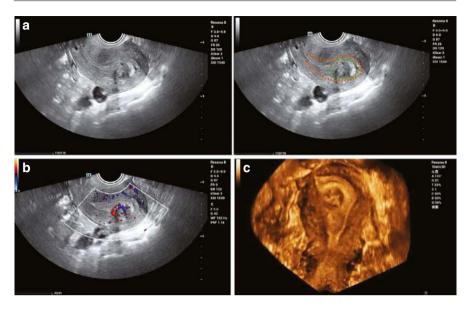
(a) Type 0 fibroid: B-mode ultrasound shows a submucosal fibroid that protrudes from the myometrium and completely emerges into the uterine cavity. The endometrium is marked in orange; the fibroid is circled in green. (b) Type 0 fibroid: Color Doppler ultrasound shows abundant blood flows in the fibroid pedicle. (c) Type 0 fibroid: Coronal plane of the uterus on 3D ultrasound shows that the fibroid is completely within the uterine cavity
